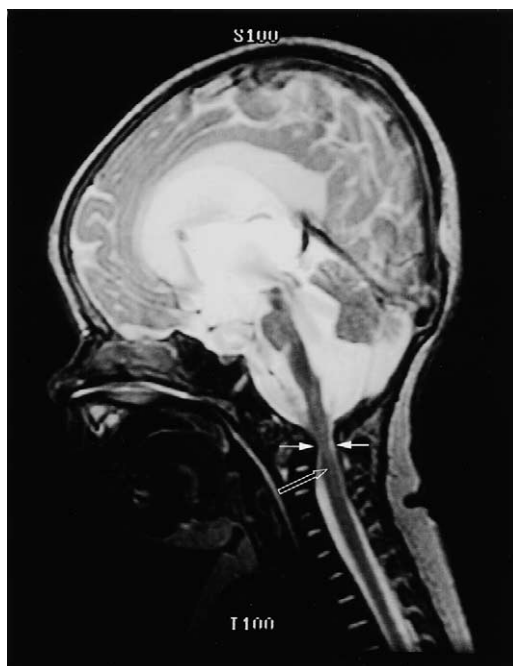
Sagittal T2-weighted MR image demonstrates marked narrowing of the space available for the spinal cord at the occipitocervical junction (*solid arrows*). High signal within the lower brainstem and upper cervical spinal cord is consistent with resolving hematomyelia (*open arrow*). Significant brain atrophy is also noted.
